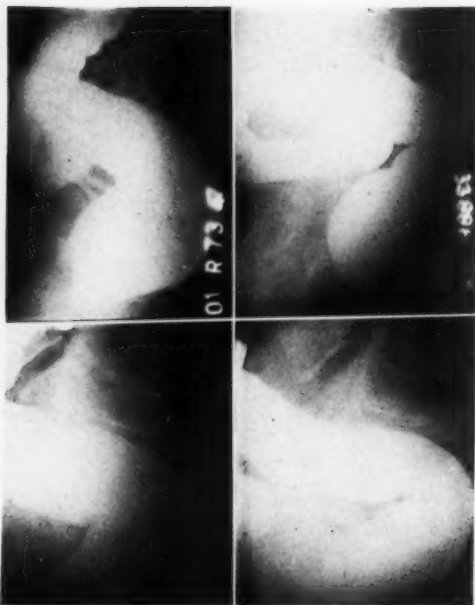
Four lateral exposures of rectum in different individuals, made without use of grid, with roentgenoscopic tube, showing normal contour of rectum in lateral projection and its relationship to the sacrum.
